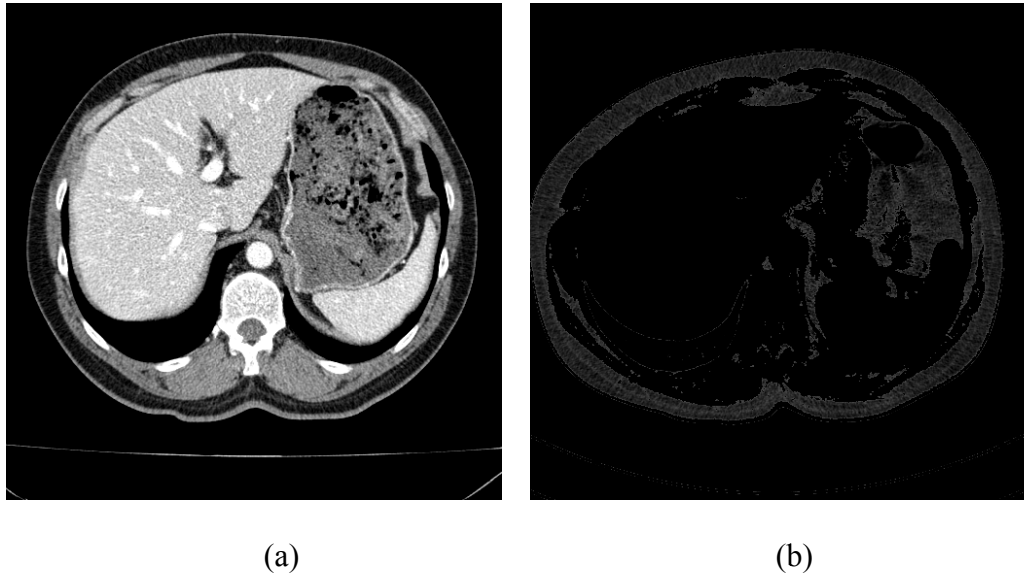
Automatic determination of the threshold to remove fat tissue (a) original abdominal CTA image (b) thresholded fat tissue.
